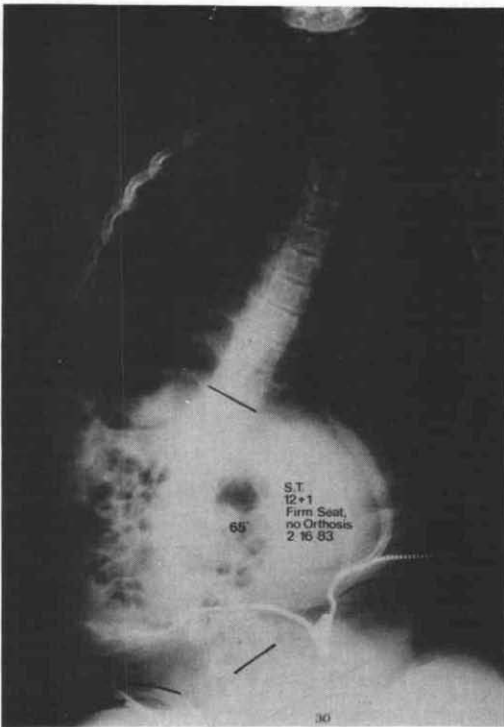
Spine x-ray of S.T. sitting unsupported as presented, showing a scoliosis of 65° and a lateral pelvic tilt of 30°.
